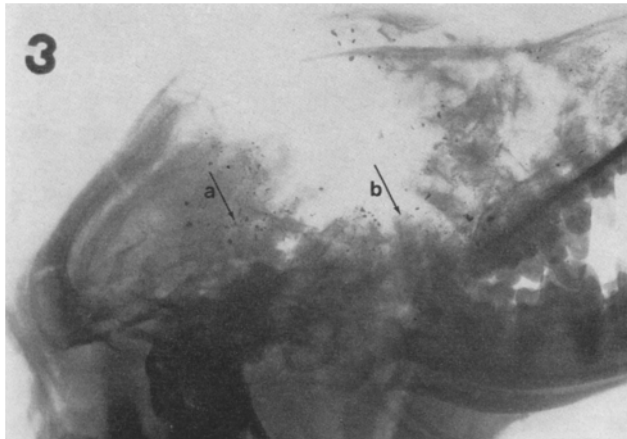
Ammunition type 2a. Central hit. The lateral, dextral radiograph shows demolition of the cranium and the posterior part of the right mandible. Multiple projectile fragments (*a*) and intra- and extra-cranial bone fragments (*b*)
